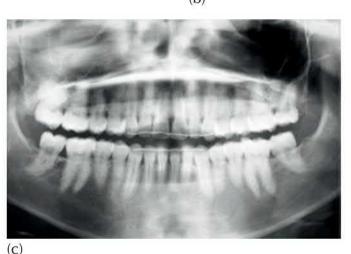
(a) Pre-treatment panoramic view at age 13.2 years showing second molar abnormality. (b) Age 16.4 years, follow-up radiograph at the end of orthodontic treatment, to assess the third molars. (c) Age 19.3 years, the three-year post-treatment follow-up panoramic view shows the final outcome.
